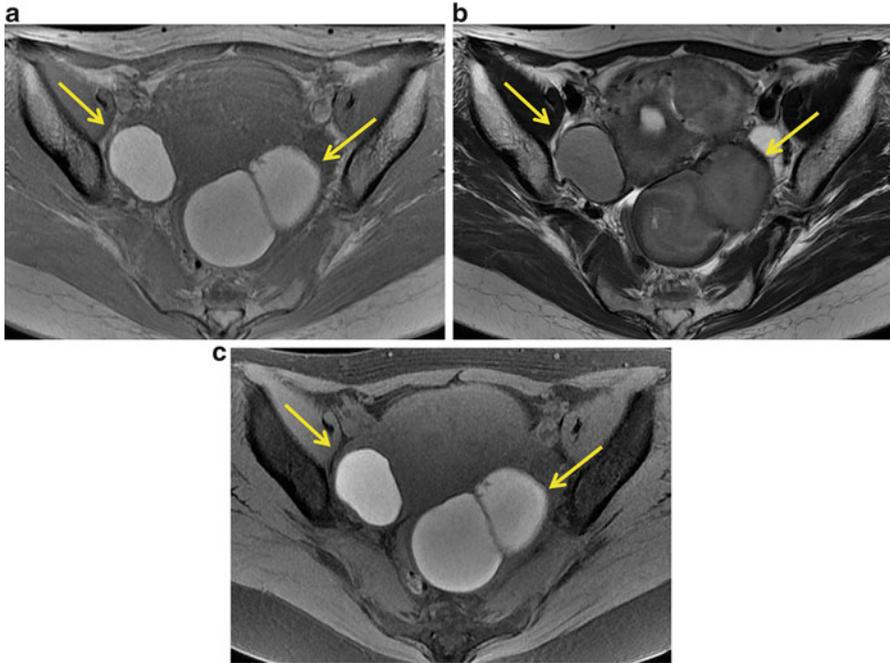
A 39-year-old woman with bilateral ovarian endometriotic cysts. Axial T1-weighted MR image (a) shows bilateral hyperintense ovarian masses (arrows). T2-weighted image shows shading with hyperintensity in both lesions (arrows) (b). On fat-suppressed T1-weighted image, these masses remain hyperintense (c)
